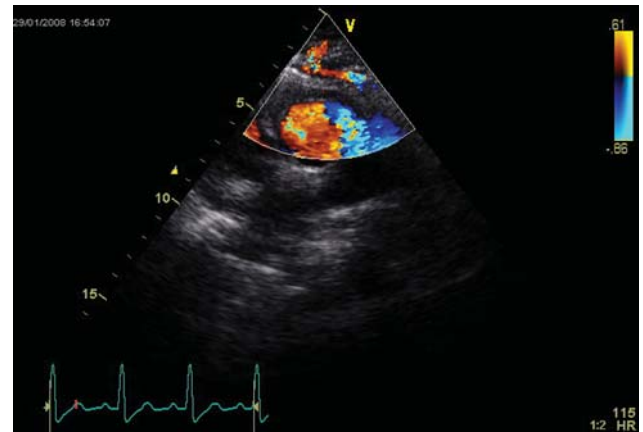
Colour-flow Doppler echocardiogram showing the tortuous trajectory followed over a distance of several centimetres.
